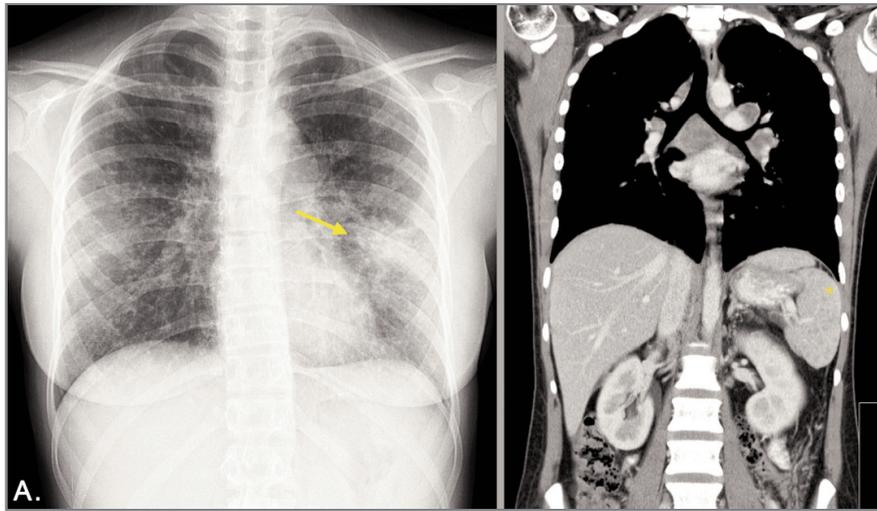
Case 2. PA chest x-rays demonstrate wide spread small nodular opacities distributed throughout both lung and air space opacification of the left lung (arrow); B. Thoraco-abdominal CT scan with normal dimensioned spleen, presenting several nodular images (*)
